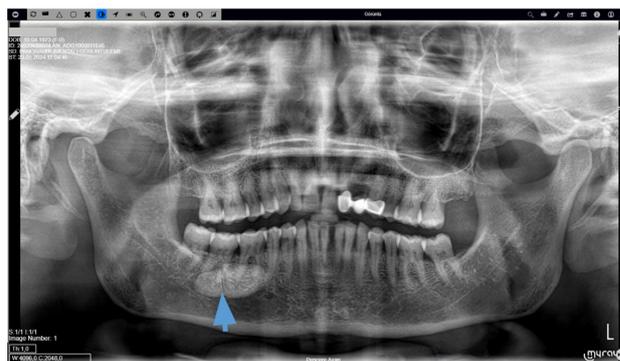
The panoramic radiograph reveals a bipartite sialolith.
